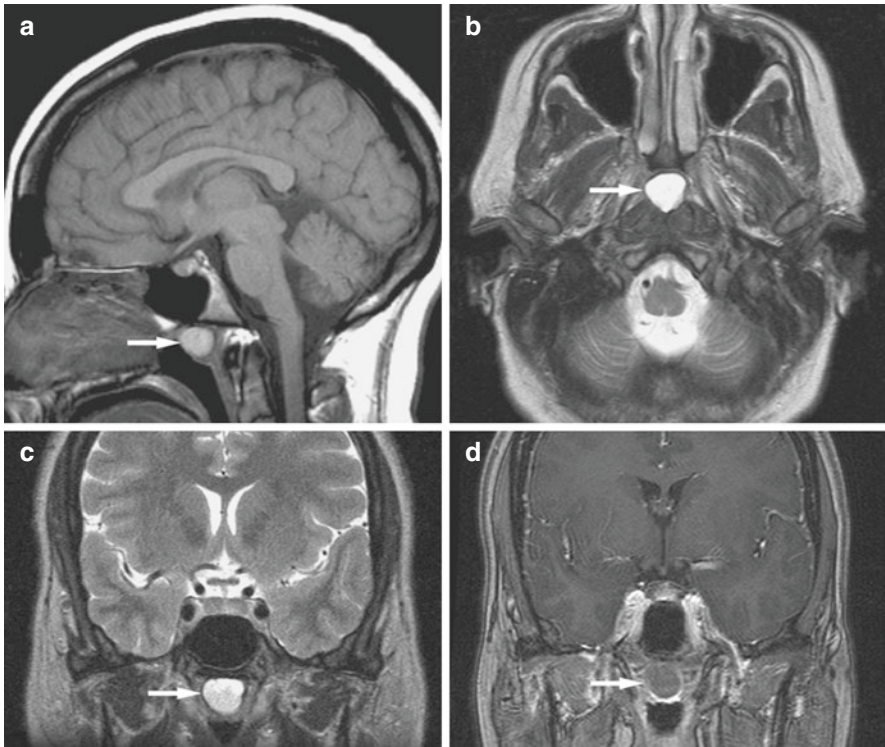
Tornwaldt's cyst, large; incidental findings in 30-year-old. (a) Sagittal T1-weighted MRI shows low-signal cyst (*arrow*) in posterior nasopharynx. (b) Axial T2-weighted MRI shows bright signal cyst (*arrow*). (c) Coronal T1-weighted MRI shows bright signal cyst (*arrow*). (d) Coronal T1-weighted post-Gd MRI shows no enhancement of the cyst (*arrow*)
